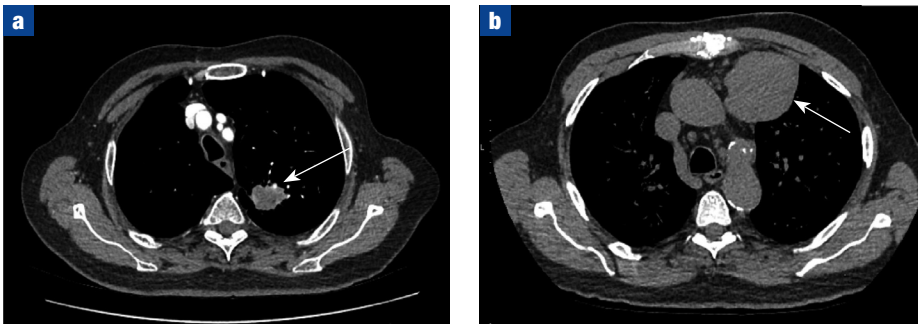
Axial computed tomography images of (a) a left upper lobe mass (arrow) which is suitable for computed tomography-guided biopsy and (b) an anterior left upper lobe mass (arrow) which abuts and invades the chest wall making it suitable for ultrasound-guided biopsy.
